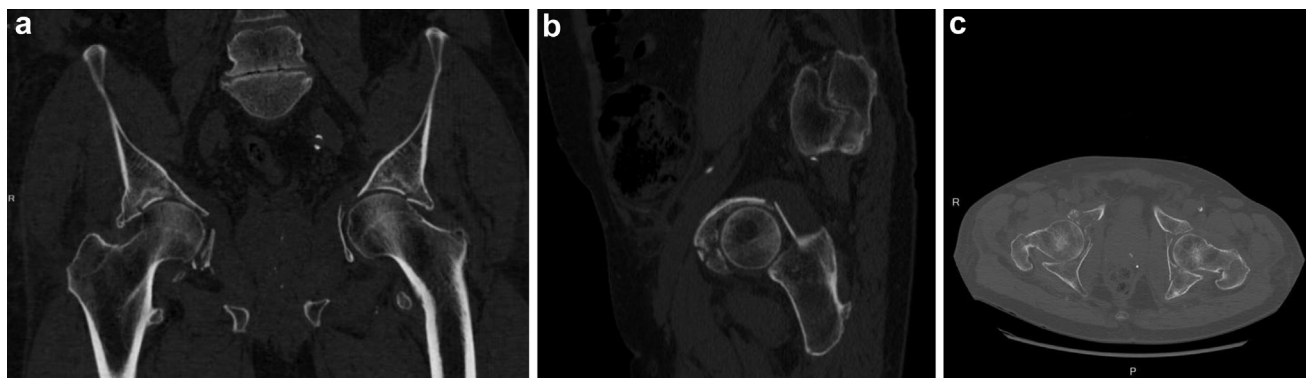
Pelvic computed tomography scan: coronal (a), sagittal (b), and axial (c) reconstructions on the right side of a fracture of the anterior and medial walls and an anterior column fracture with a minimal displacement and on the left side a fracture of both anterior and posterior column with a superior and medial displacement.
